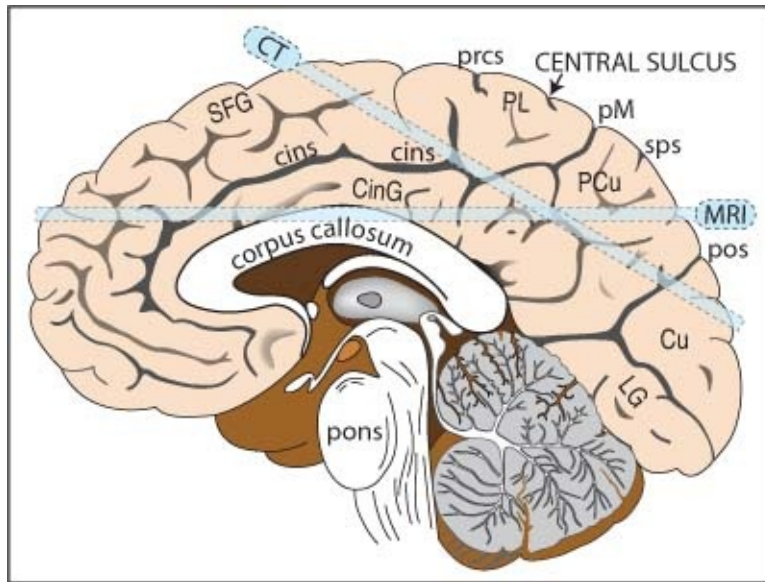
Medial aspect of the right hemisphere “CT” & “MRI” bars depict typical axial slice orientation for CT & MRI scans. See [Table 5-1](#) and [Table 5-2](#) for abbreviations
